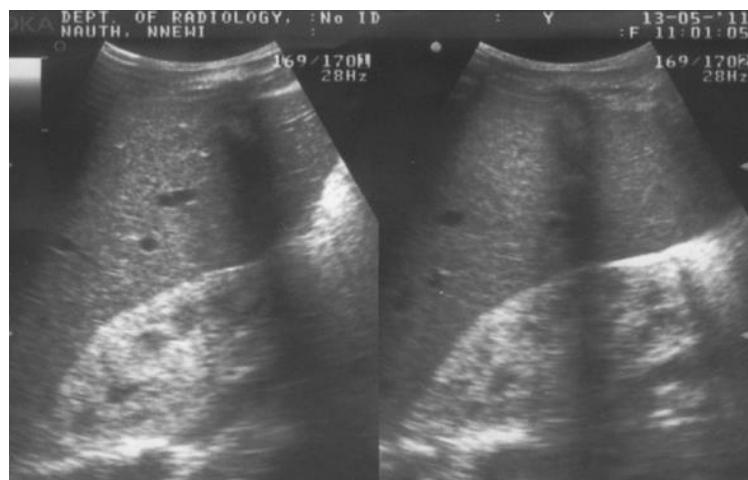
Sonogram showing the kidneys with chronic renal failure in a patient with HIV/AIDS. Note the echogenic kidneys and loss of corticomedullary distinction.
